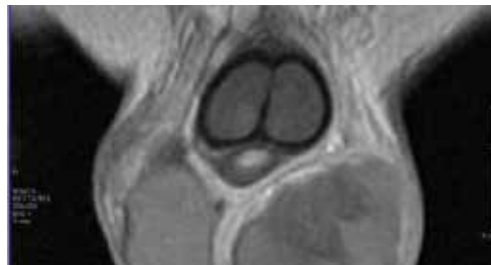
choriocarcinoma-MRI
